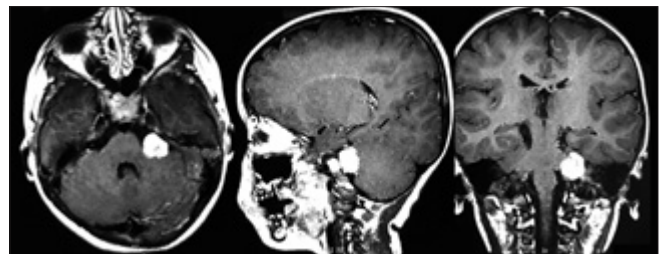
MRI of the brain contrast study axial, sagittal, and coronal section shows contrast enhancing extra-axial lesion
